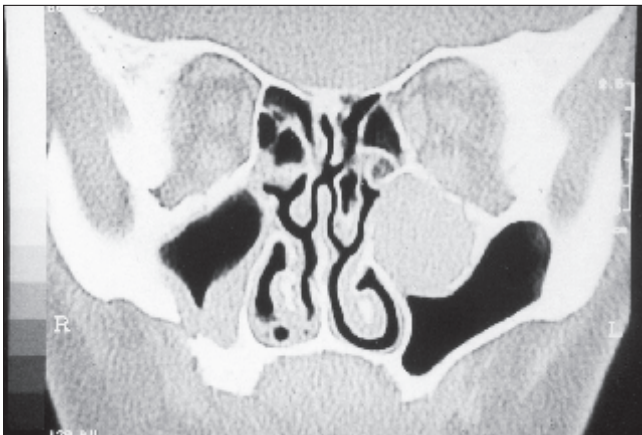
Coronal CT scan showing a mucocele in a Haller's cell on the left side.
